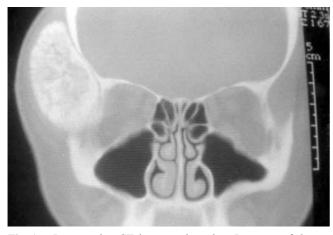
Preoperative CT in coronal section. Presence of the tumour at the pterion
